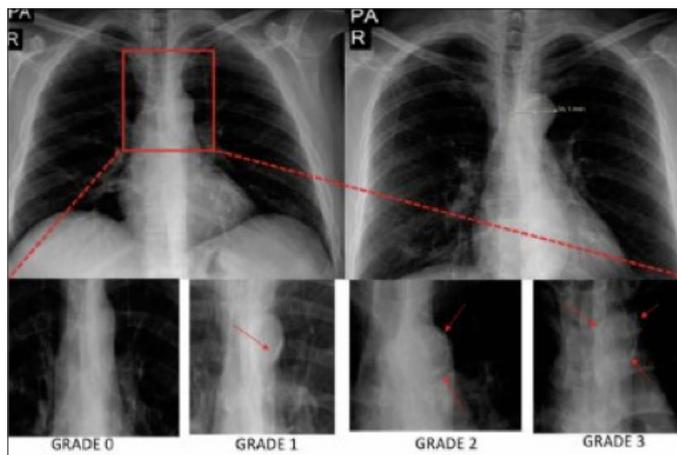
Postero-anterior chest radiography view of aortic knob width assessment and grading of aortic knob calcification.
